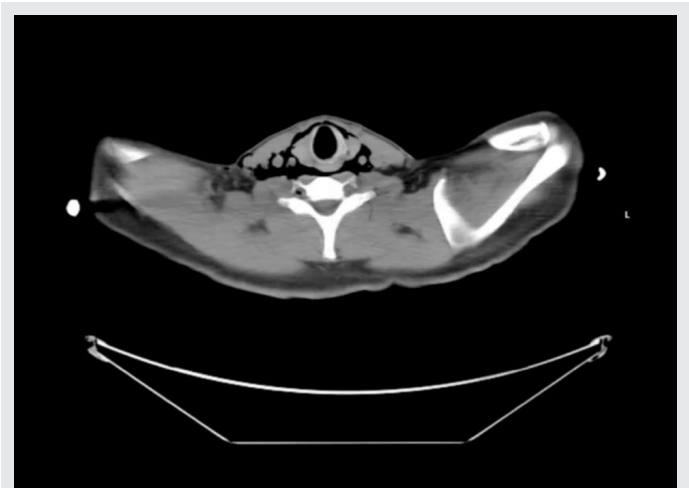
CT esophagography shows the retropharyngeal soft tissues dissecting through the myofascial plane, which communicate with the soft tissues of the base of the neck and supraclavicular region.
